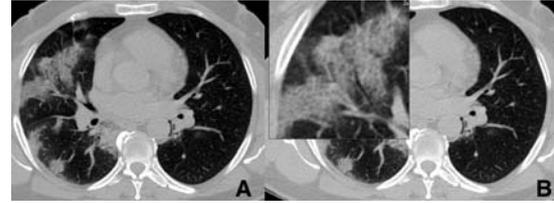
CT images of a 53-year-old female with COVID-19. The patient presented with fever and the CT shows areas of crazy paving (A and zoomed image in B) in the periphery with linear opacities overlying the GGO.
